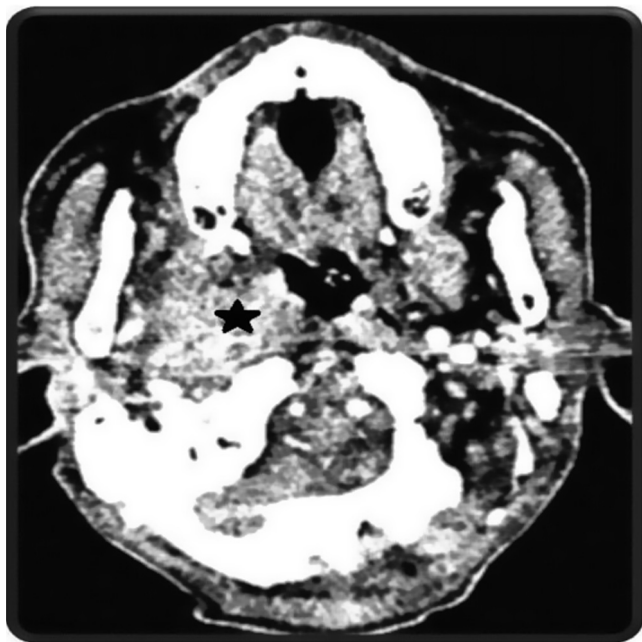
Contrasted CT scan showing soft tissue density at the right FOR with extension to the right parapharyngeal space (star).
